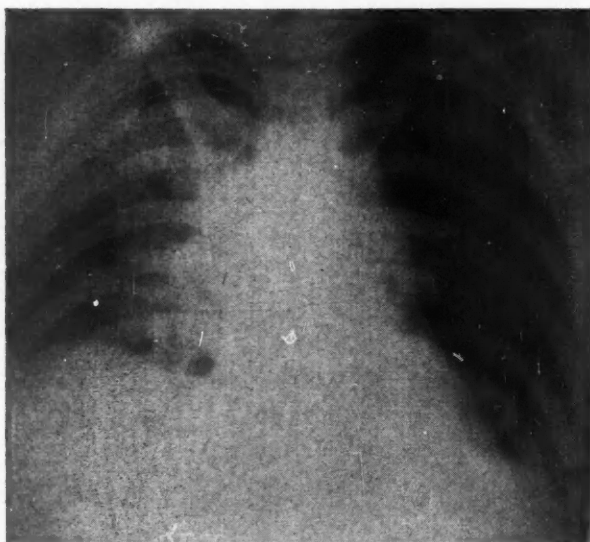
(Case 1).—Diffuse haziness in lung fields due to fat embolism. (Portable x-ray).
